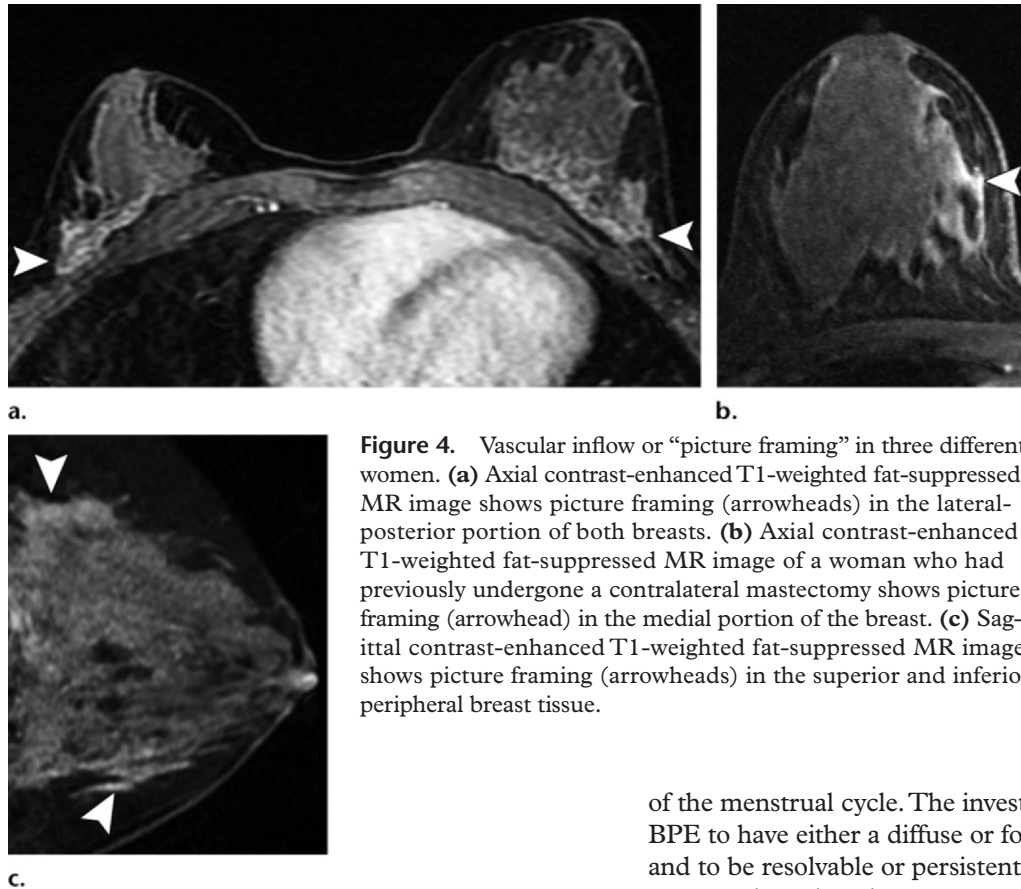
Vascular inflow or “picture framing” in three different women. (a) Axial contrast-enhanced T1-weighted fat-suppressed MR image shows picture framing (arrowheads) in the lateral-posterior portion of both breasts. (b) Axial contrast-enhanced T1-weighted fat-suppressed MR image of a woman who had previously undergone a contralateral mastectomy shows picture framing (arrowhead) in the medial portion of the breast. (c) Sagittal contrast-enhanced T1-weighted fat-suppressed MR image shows picture framing (arrowheads) in the superior and inferior peripheral breast tissue.
